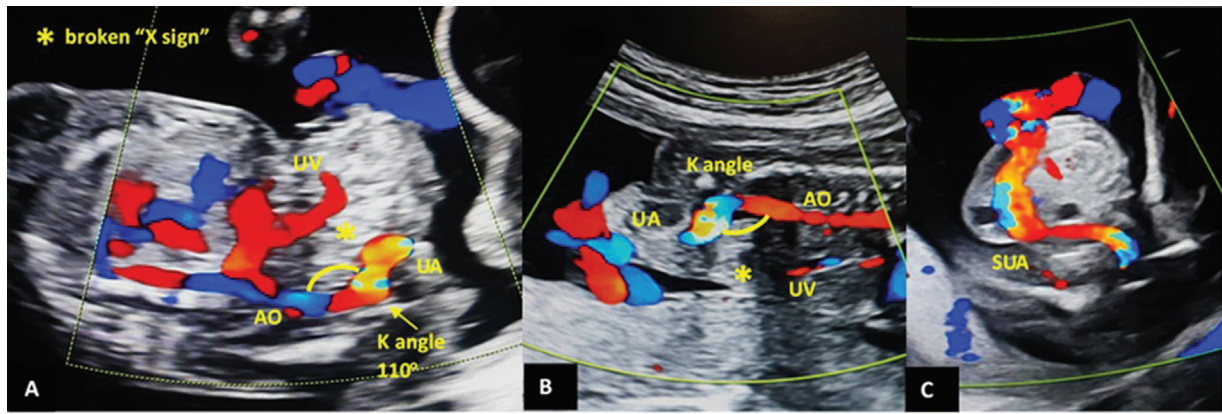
(A–C) Color Doppler in sagittal view (supine and prone) shows altered course of intrafetal umbilical artery (UA) with widening of “K angle,” broken “X-sign” (*), and distorted equilateral triangle (aorta [AO]-umbilical artery [UA]-umbilical vein [UV]). Transverse-pelvic view shows divergent single-umbilical artery (SUA) emerging below the ventral mass.
